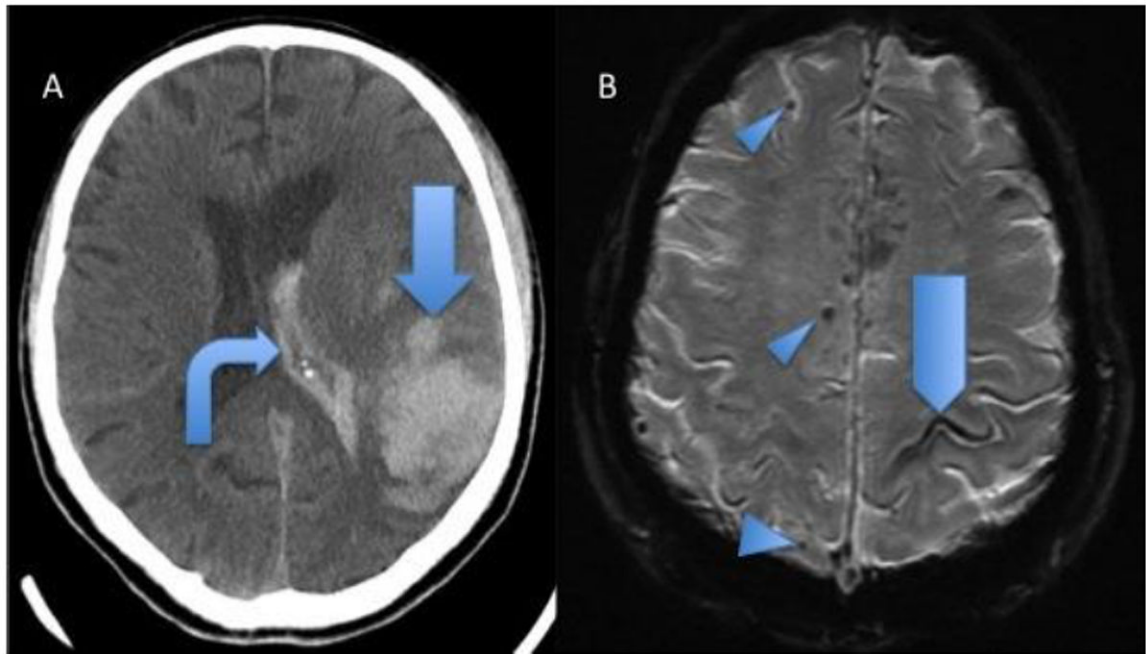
Hemorrhagic findings of 2 patients with pathologically proven cerebral amyloid angiopathy. A, Head CT showing acute lobar parenchymal macrobleed (*arrow*) and intraventricular hemorrhage (*bent arrow*). B, GRE MRI shows lobar microbleeds (*arrowheads*) and sulcal siderosis (*pentagon*).
